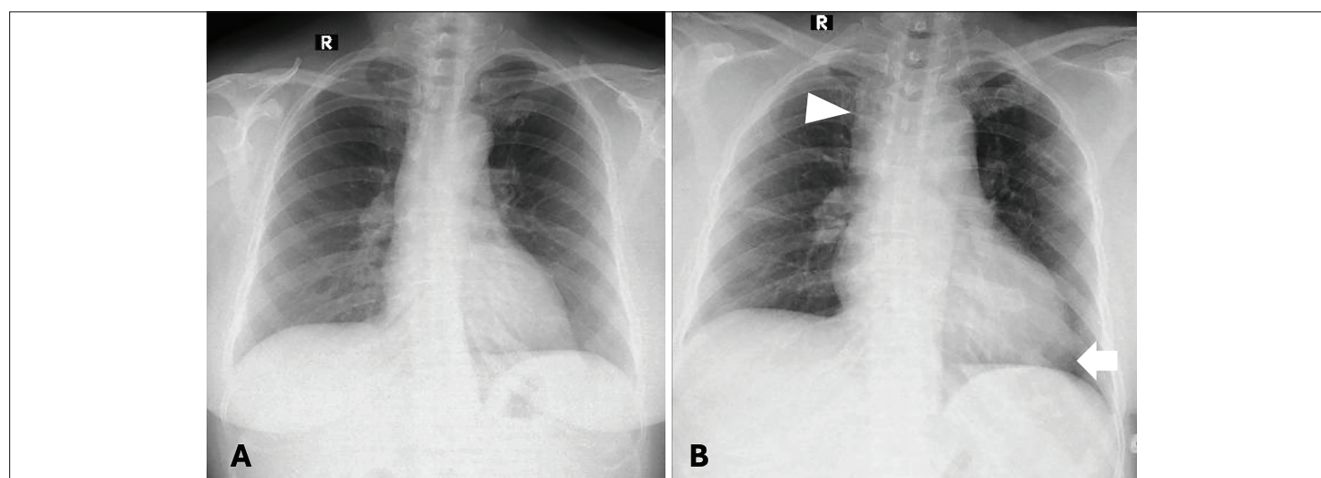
Comparison of chest X-ray before and after operation. Preoperative chest X-ray (A) was normal. On postoperative X-ray, cardiomegaly with rounded left heart border and uplifted cardiac apex was appreciated, compatible with right ventricle dilatation (arrow). Widening of the right paratracheal stripe was also noted, suggesting an enlargement of the superior vena cava (arrowhead).
